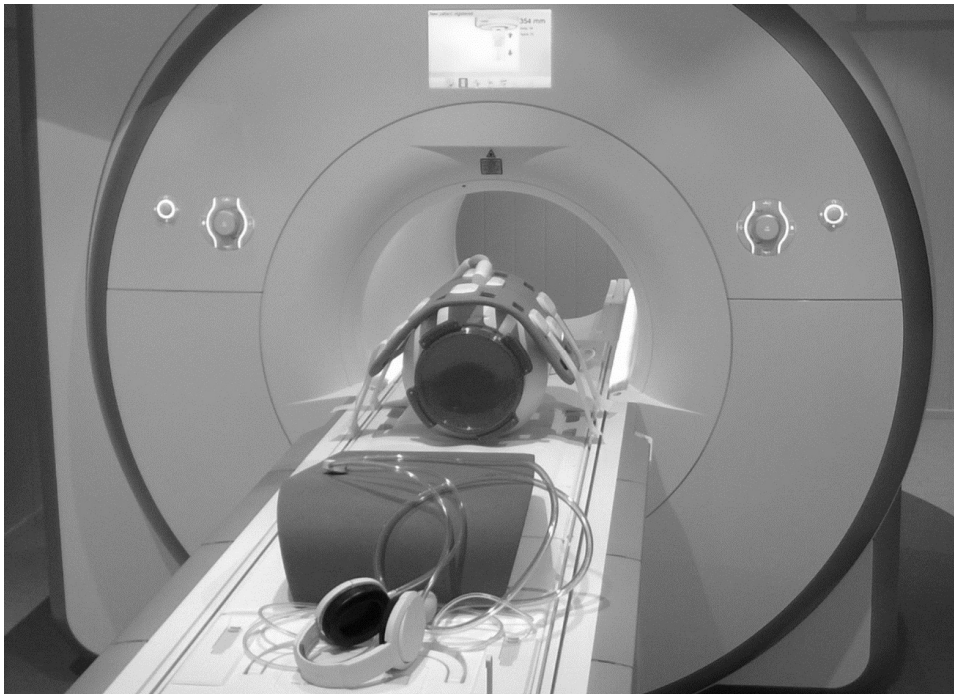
A test object positioned on an imaging table of an MRI system.*
